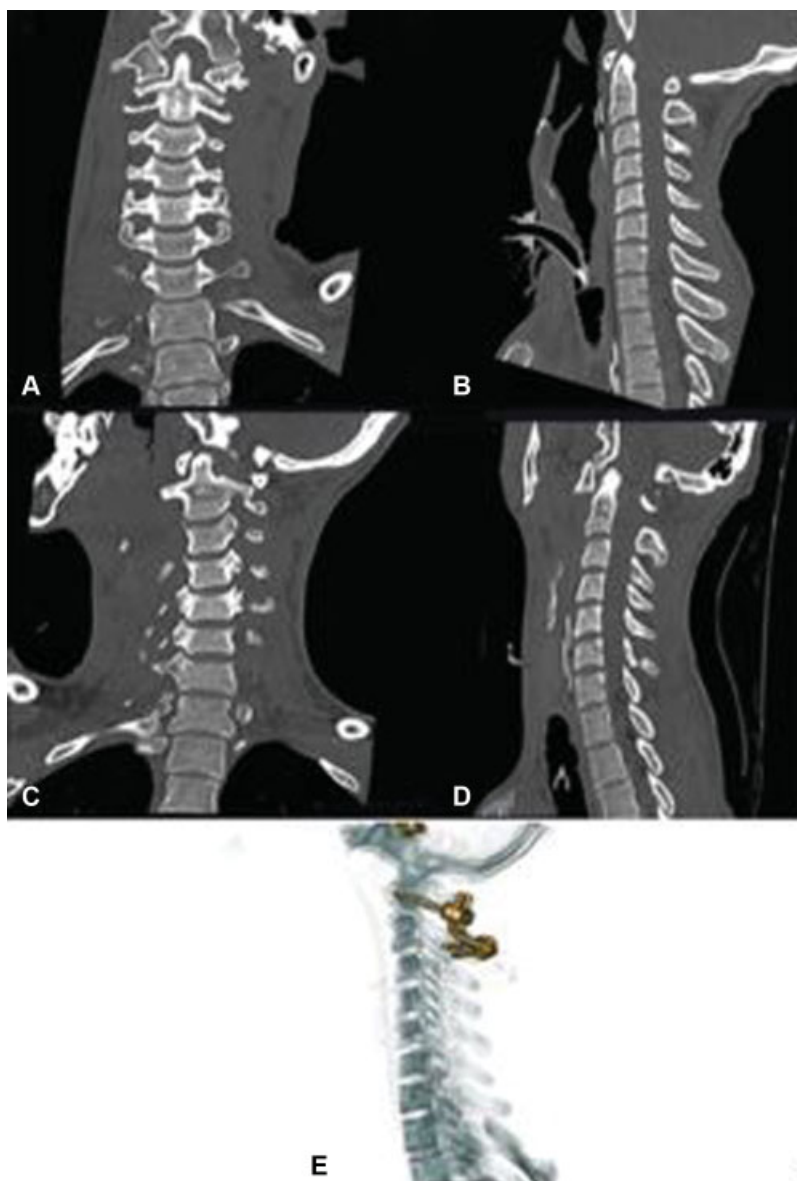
(A and B) CT at admission, coronal and sagittal images respectively. Good cervical spine alignment and fracture of the C7 transverse process are noted. (C and D) CT of the 34th day of hospitalization, when the patient began to present a vicious cervical posture. There was a dislocation between C1 and C2 and an increase in the atlanto-dental interval in the sagittal section. (E) 3D CT for postoperative control after the patient underwent posterior cervical arthrodesis with lateral mass screws in C1 and lamina in C2.
